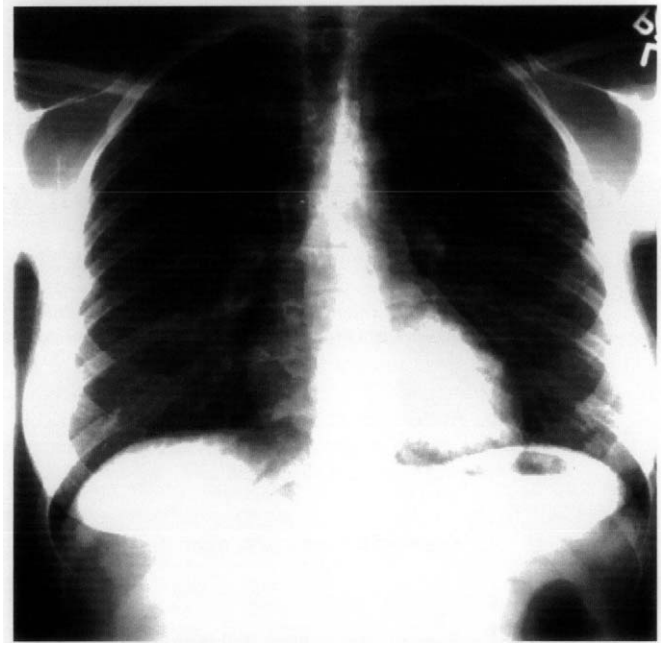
Chest radiograph after extubation demonstrates radio graphic improvement.
